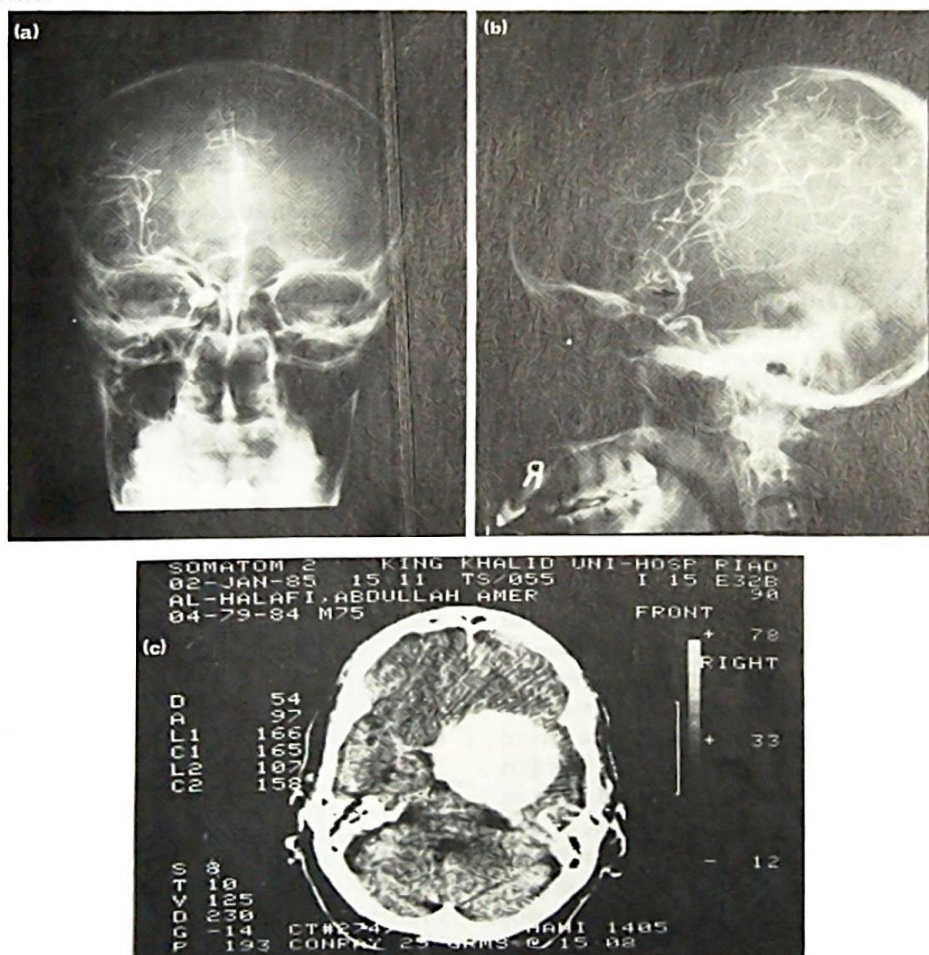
(a) Antero-posterior view showing medial displacement of the middle cerebral artery and with minimal shift of the anterior cerebral artery by a sphenoid wing meningioma extending posteriorly. The proximal segment of the anterior cerebral artery is slightly elevated. (b) Lateral view of same patient showing subfrontal extension. Posterior displacement of the post-clinoid carotid artery and the proximal portion of the anterior carotid artery (\uparrow) and with elevation of middle cerebral artery. (c) CT scan of same patient. Large homogenous tumour in the right middle fossa extending subfrontally and medially compressing the suprasellar cistern.
